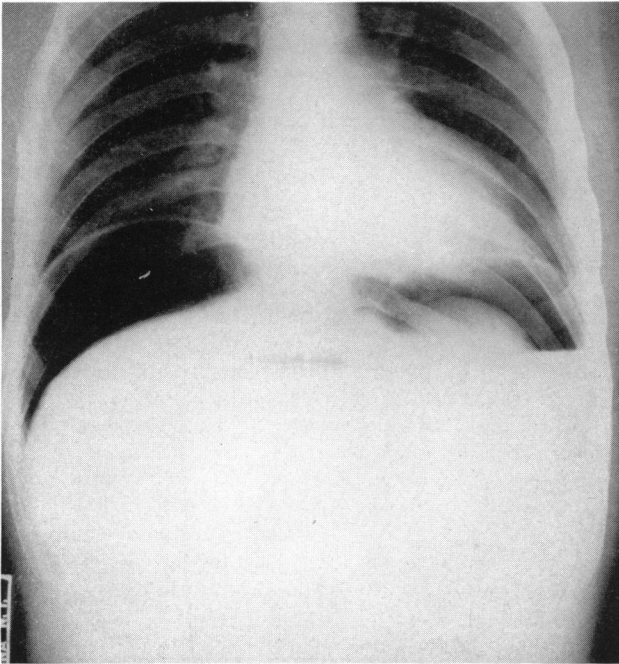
Case 3: Preoperative roentgenogram; sitting up. Shows gas beneath the diaphragm.
